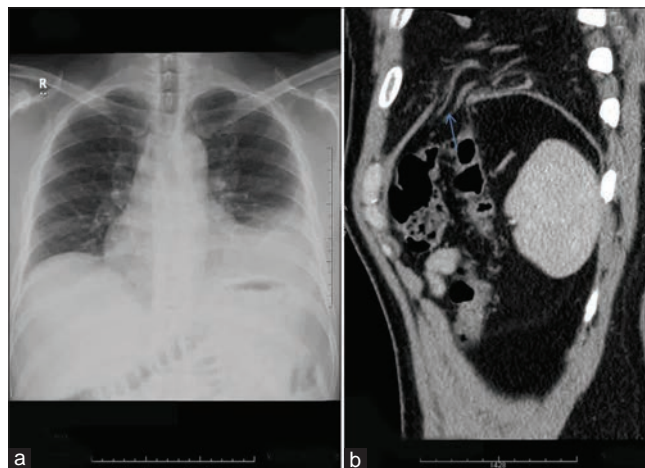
(a) Chest X-ray suggestive of left pleural effusion. CT scan (b) Defect in left hemidiaphragm (blue arrow) with herniation of omentum into the chest
